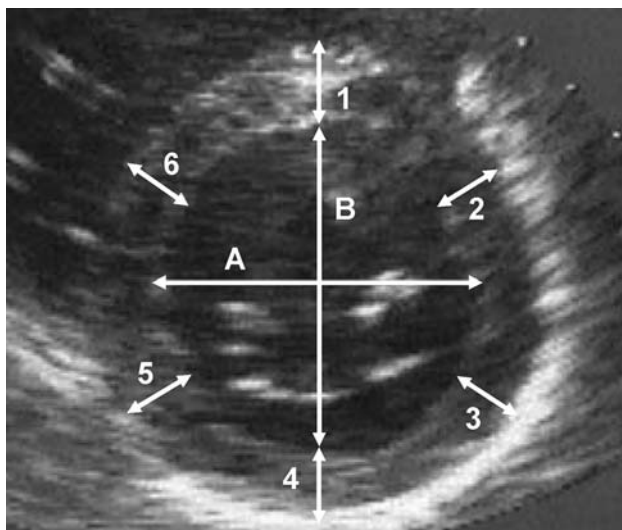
Representative echocardiographic short-axis view. Six regions are indicated for wall thickness determination (arrows) and the inner diameter of the left ventricle (LV). The LV diameter was determined bidirectionally as the mean of diameters A and B
